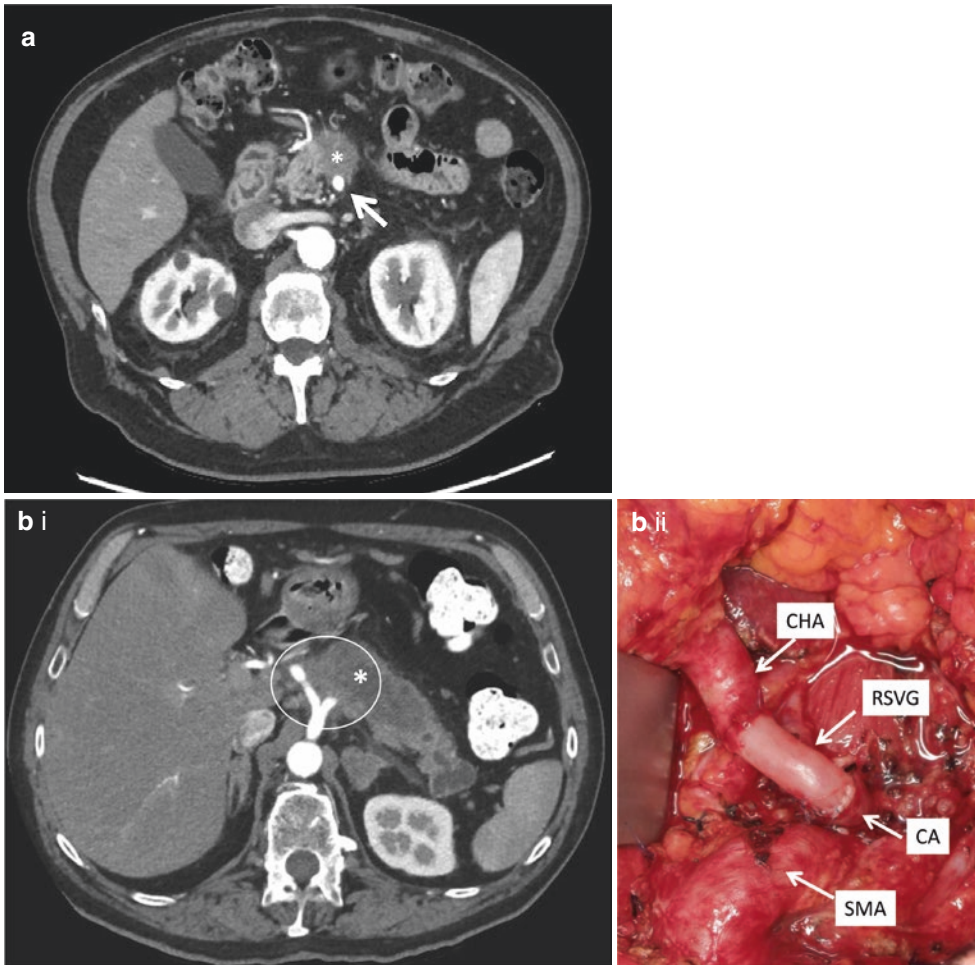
Locally advanced Type A pancreatic cancer. (a) Axial computed tomography image of a locally advanced pancreatic neck tumor that involves the SMA >180° but <270° and is therefore considered Type A and potentially resectable (arrow points to SMA; asterisk marks tumor). (b) (i) Axial computed tomography image of a pancreatic body tumor that involves the bifurcation of the celiac axis into the common hepatic artery and splenic artery. The celiac trunk is uninvolved making this tumor potentially resectable (asterisk marks tumor; circle encompasses celiac axis). (ii) We prefer to revascularize (“supercharge”) the common hepatic artery by placing a reverse saphenous vein graft between the celiac trunk and distal common hepatic artery just before the takeoff of the gastroduodenal artery as shown in this intraoperative photograph. This maneuver restores forward arterial flow through the common hepatic artery therefore not relying
